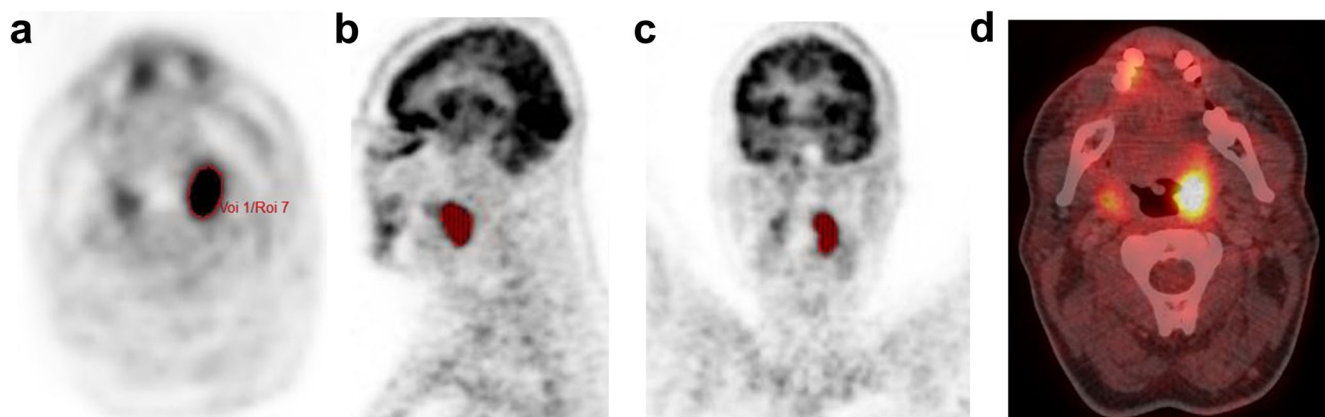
[^{18}F]FDG-PET/CT findings in a patient with HNSCC of the left oropharynx. Lesion with polygonal volume of interest (VOI) in the a axial, b sagittal, and c coronal planes. $\text{SUV}_{\text{max}} = 10.6$, $\text{SUV}_{\text{mean}} = 6.2$. d Fused [^{18}F]FDG-PET/CT image demonstration of the metabolic active HNSCC of the left oropharynx (arrow).
